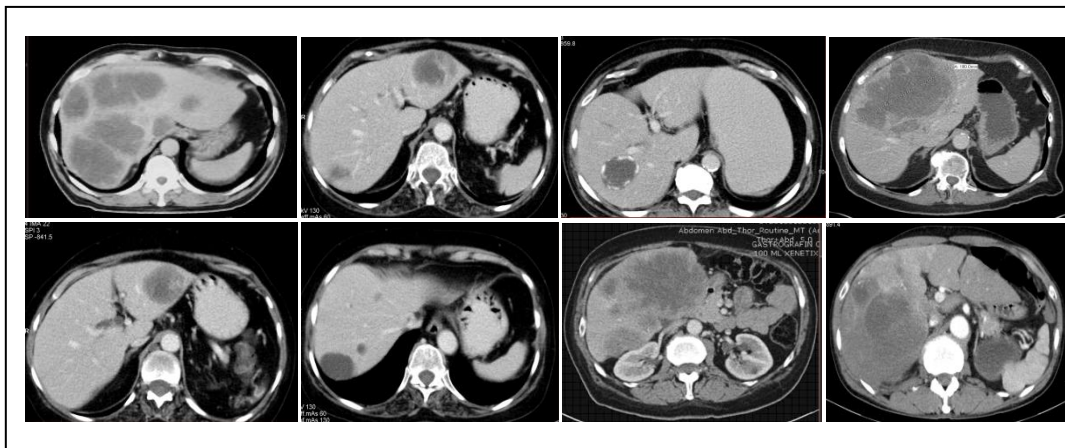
Dataset of greyscale CT images for liver cancer patients.
